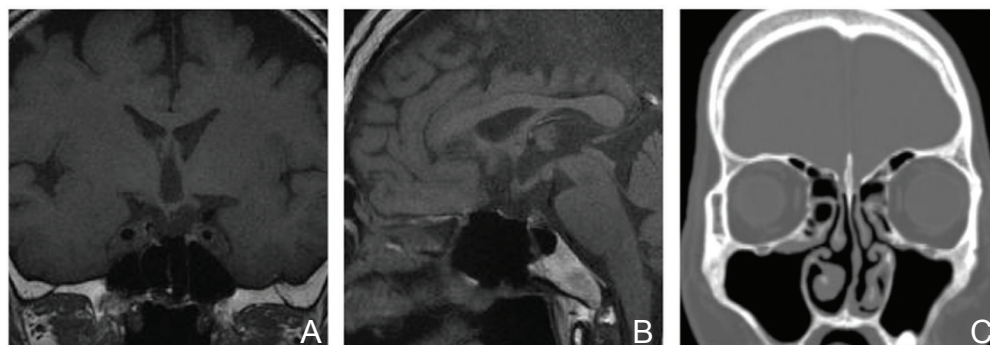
Case 2. Postoperative coronal (A) and sagittal (B) T₁-weighted magnetic resonance images and coronal computed tomography scans (C). The cyst has disappeared and good decompression of the optic chiasm is achieved (A, B). The chronic sinusitis in the right maxillary sinus has also improved (C).
